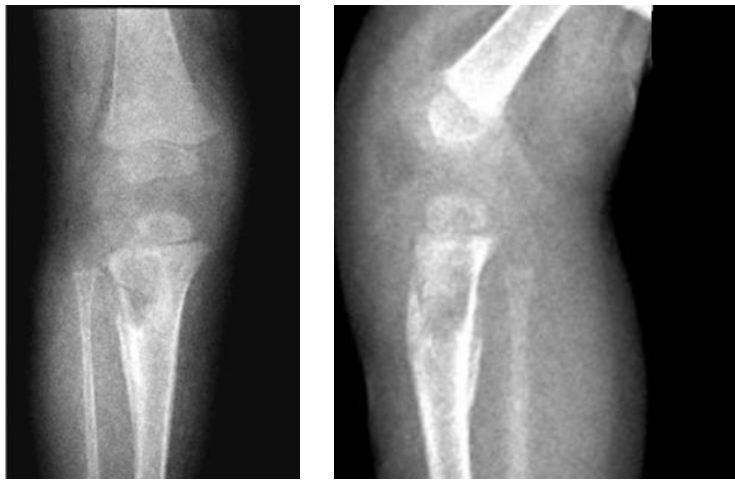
Right knee x-ray AP/lateral view post operation
